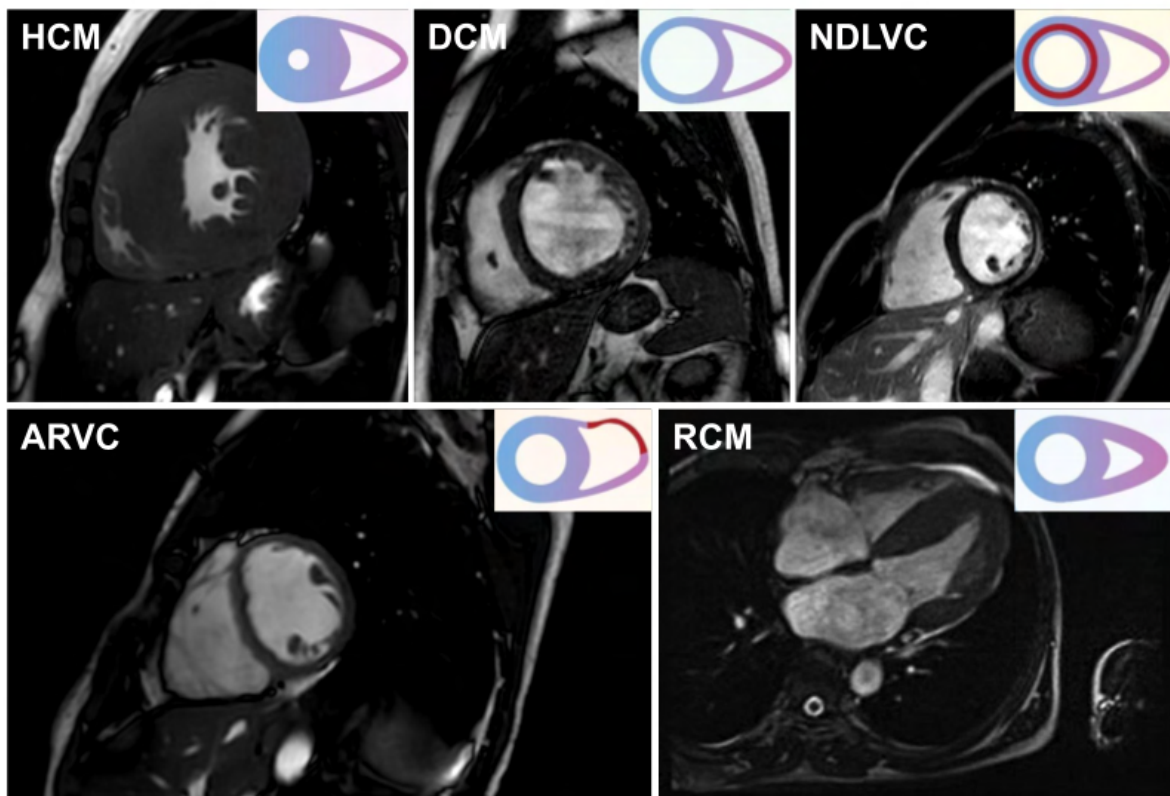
Cardiac magnetic resonance images of different cardiomyopathies. The first four images correspond to patients of the cohort analysed in this thesis while the restrictive cardiomyopathy one was extracted from Muchtar et al. (2017). The graphical representations were extracted from Arbelo et al. (2023). Abbreviations: HCM = hypertrophic cardiomyopathy; DCM = dilated cardiomyopathy; NDLVC = non-dilated left ventricular cardiomyopathy; ARVC = arrhythmogenic right ventricular cardiomyopathy; RCM = restrictive cardiomyopathy.
